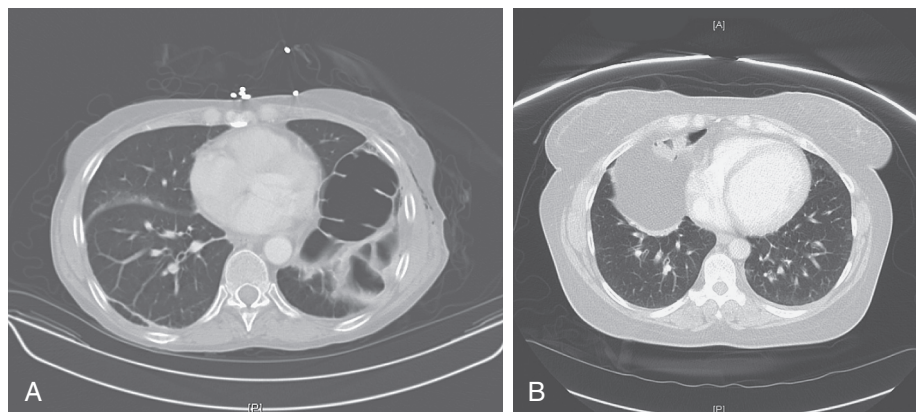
■ A, CT scan of left diaphragmatic elevation. Note the lung tissue at the anterior and posterior thorax. B, CT scan of Morgagni hernia. Note the lack of lung tissue at the extreme hemithorax.
